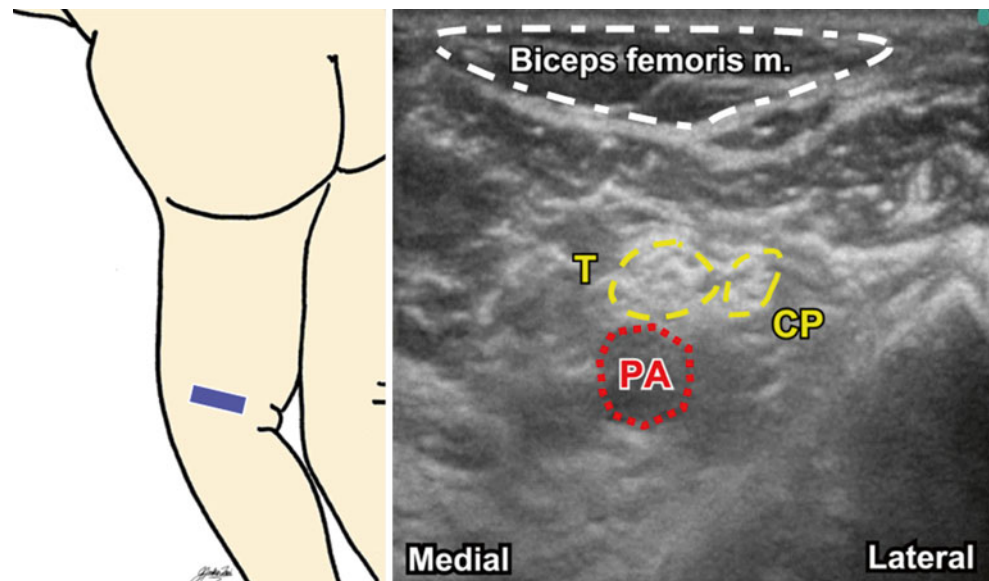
Ultrasound image of the popliteal sciatic nerve block location. *T* tibial nerve, *CP* common peroneal nerve, *PA* popliteal artery
